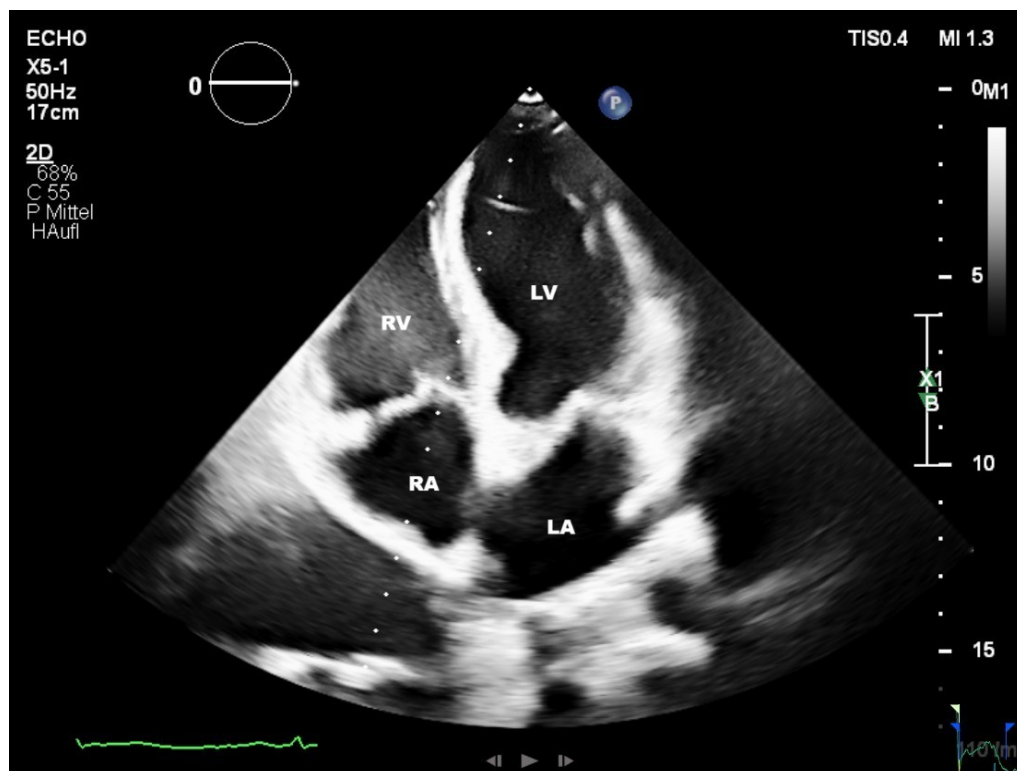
Apical four chamber view. LV, Left ventricle; RV, Right ventricle; LA, Left atrium; RA, Right atrium; MV, Mitral valve; TV, Tricuspid valve
